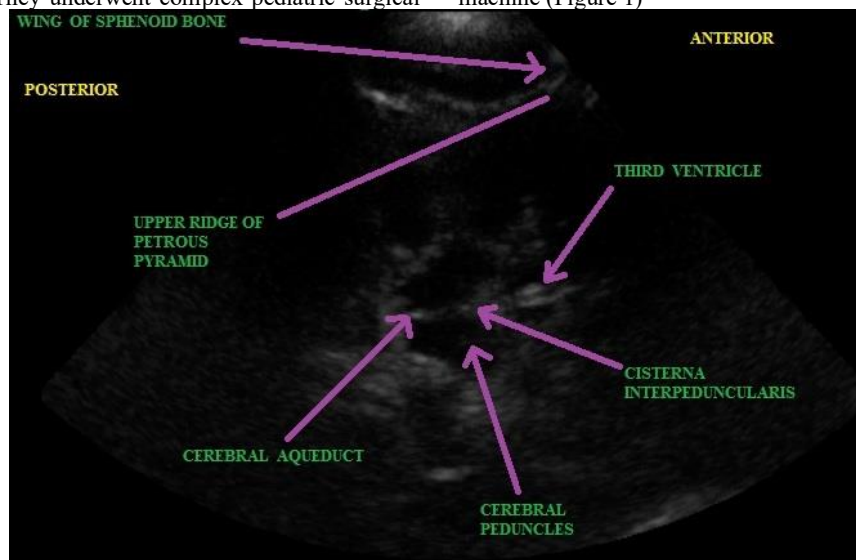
The sonoanatomical landmarks while observing the third ventricle of the brain using phased array transducer of Sonosite ultrasound machine.
